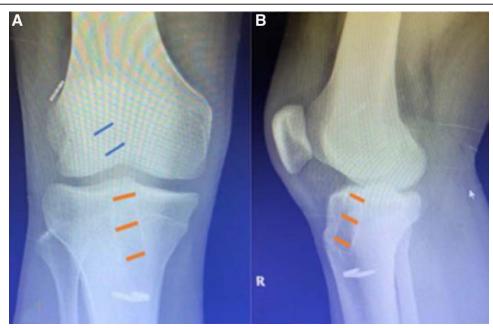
Radiological measurements. (A) Measurement of tibial and femoral tunnel enlargement in AP radiography. Measurement locations are marked in red in the tibal tunnel and blue in the femoral tunnel. (B) Measurement of tibial tunnel enlargement in lateral radiography. Measurement locations are marked in red in the tibal tunnel. AP = anterior—posterior.
